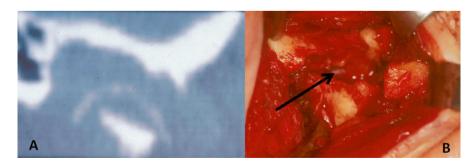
(a) Sagittal CT image of a right TMJ demonstrating the osseous damage resulting from the foreign body reaction to a failed Proplast-Teflon interpositional implant. (b) Intraoperative image of this joint at removal of the failed Proplast-Teflon interpositional implant. Note the loss of the zygomaticotemporal component of the zygomatic arch and perforation of the glenoid fossa into the middle cranial fossa (*arrow*)
